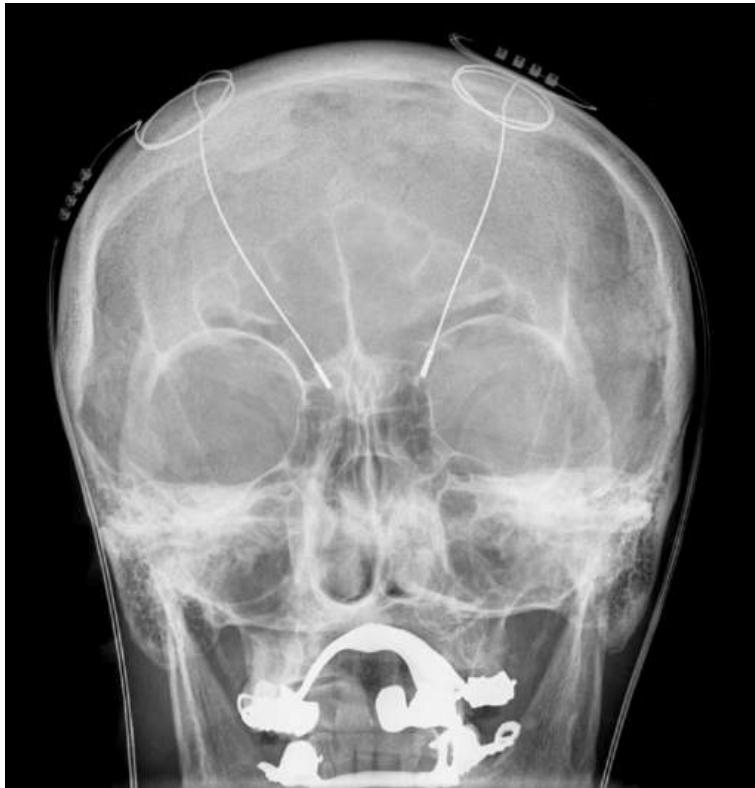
Deep Brain Stimulation probes shown in an X-ray of the skull.
